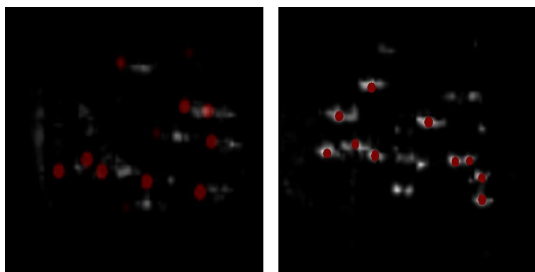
Overly of TRUS and CT images on the same plane before (left) and after (right) registration
